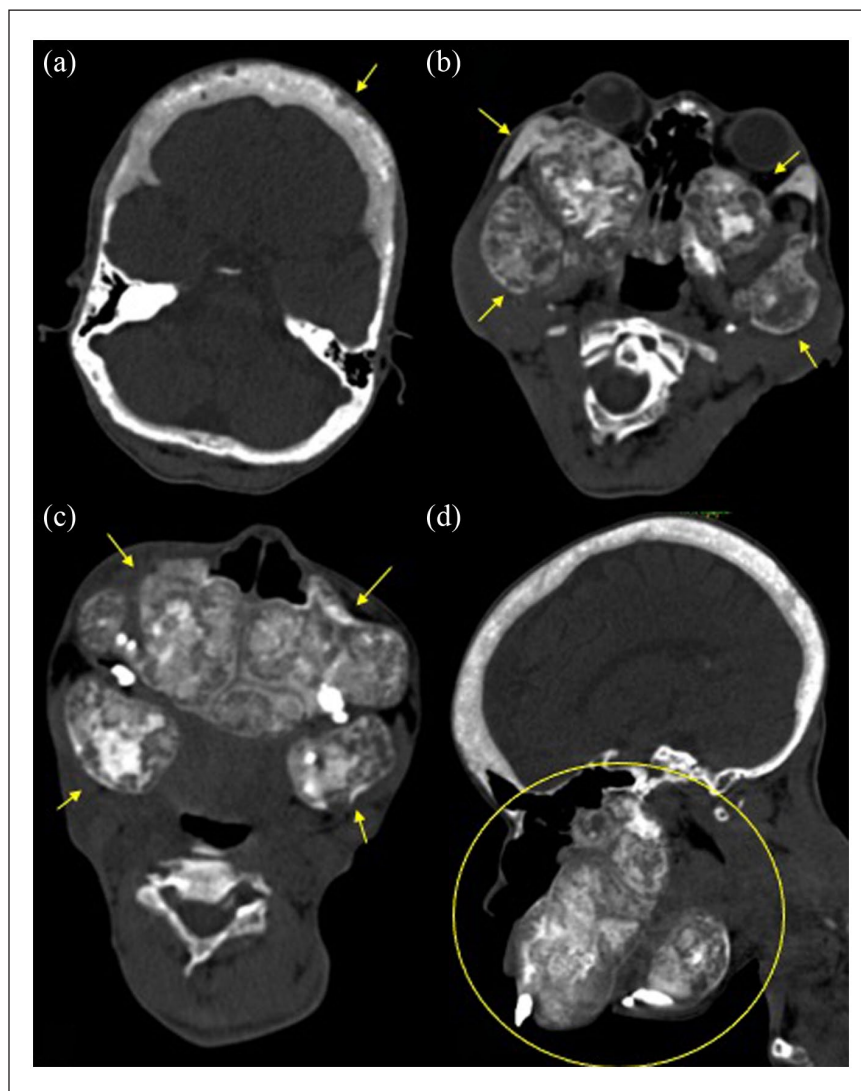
CT scan of the face and skull in bone window with both axial (a, b, c) and sagittal (d) images showing a massive hypertrophy with diffuse lytic and sclerotic lesions of the maxillary bone, mandibular bone, and cranial vault, without periosteal reaction or invasion of adjacent soft tissues. The lamina dura lysis of the alveolar bone gives the teeth a floating aspect.
